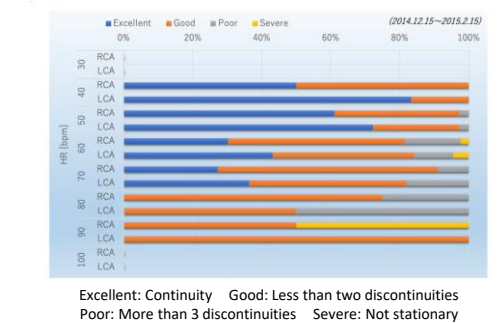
Success rate of coronary artery CT exams at our hospital
